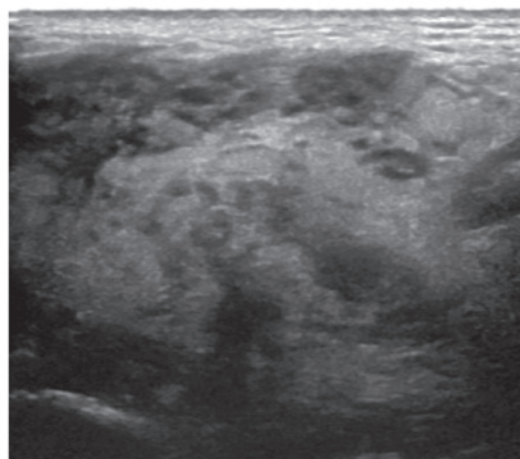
Ultrasound of the right parotid gland region showing uneven echogenicity.
